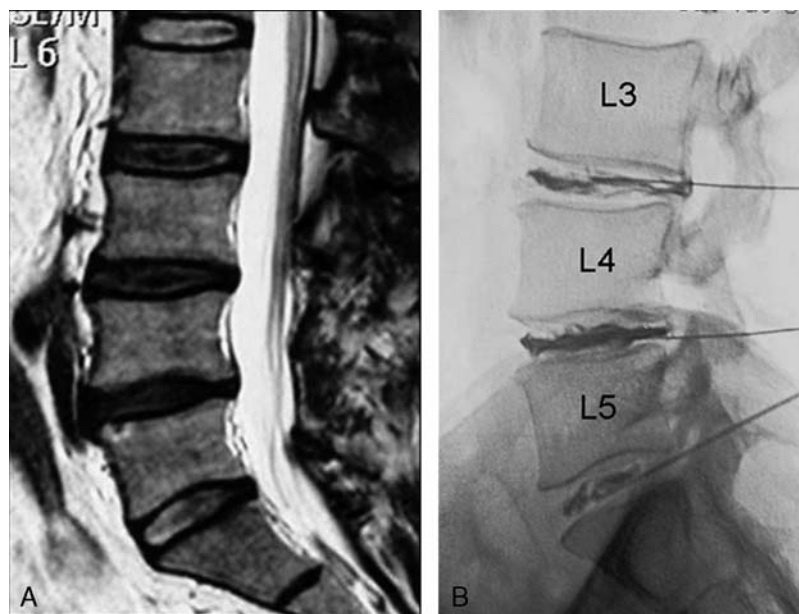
A 45-year-old man had suffered from chronic LBP for 1 year. Sagittal (A) T2-weighted MR images showed grade IV degeneration at the L3-to-L4 and L4-to-L5 intervertebral disk levels. B, Lateral discograms showed a ruptured pattern of Type V at L3-to-L4 intervertebral disk levels, and a fissured pattern of Type IV at L4-to-L5 levels; the patient had concordant pain at these 2 levels during discography.
